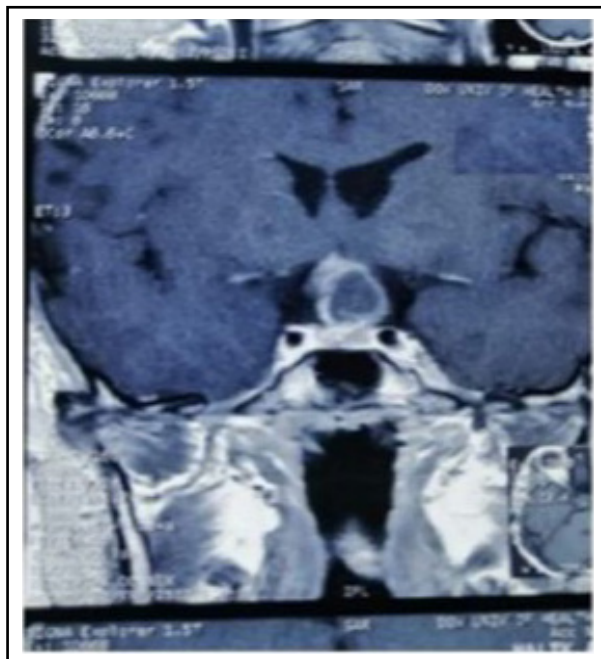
MRI Pituitary showing slight reduction in size of Suprasellar mass: Slight reduction in previously identified solid cum cystic mass in Suprasellar region measuring $2.5 \times 1.8 \times 1.3$ cm, superiorly compressing optic chiasma.
